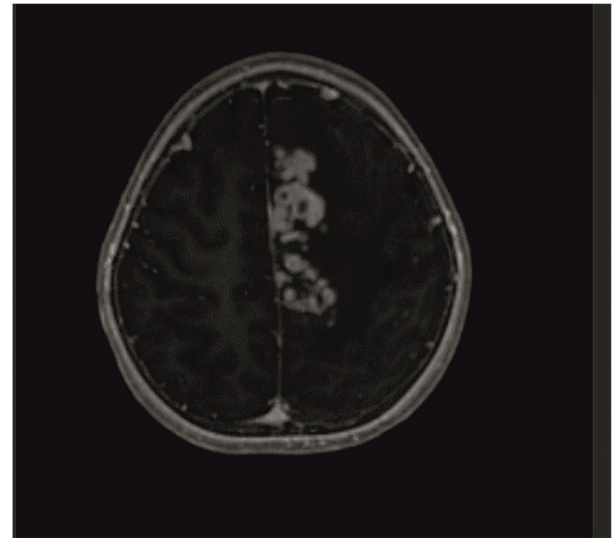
Contrast-enhanced brain MRI was performed in April 2022. Axial contrast-enhanced section, at the level of the centrum semi-oval in the left frontoparietal, showing numerous lesions, most of which have peripheral ring-shaped contrast enhancement, are located close to each other and have widespread edema around them. Some are nodular.
